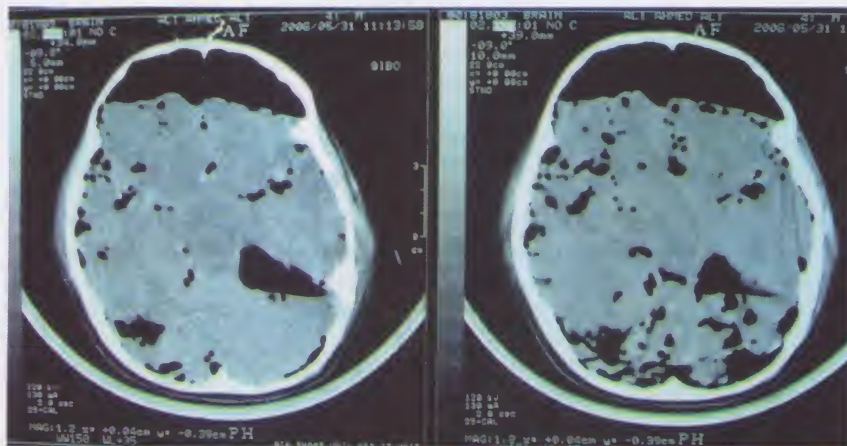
A CT brain showing pneumocephalus with air seen in the subarachnoid spaces and basal cisterns due to wrong ventilation in the brain through a previously inserted nasal tube
